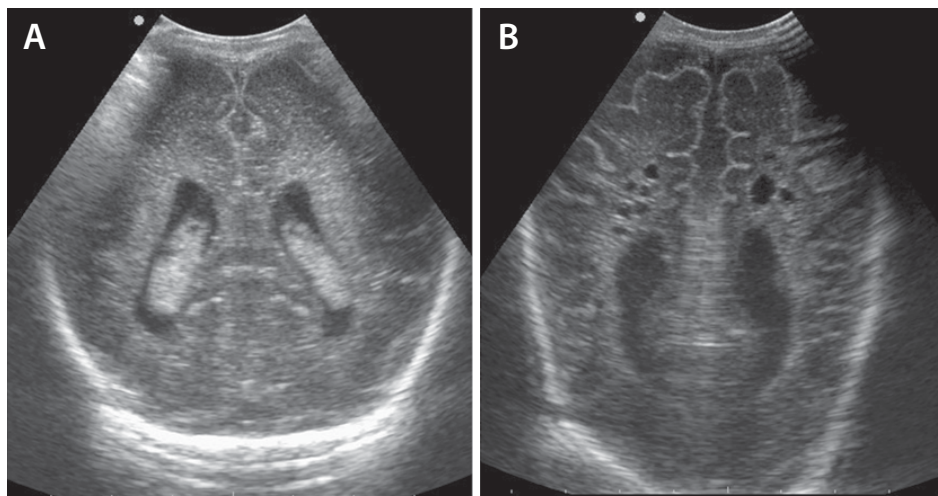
Minor and major brain abnormality on ultrasound images: A) Periventricular echodensities/ mild PVL (grade 1); B) Cystic form of PVL.
